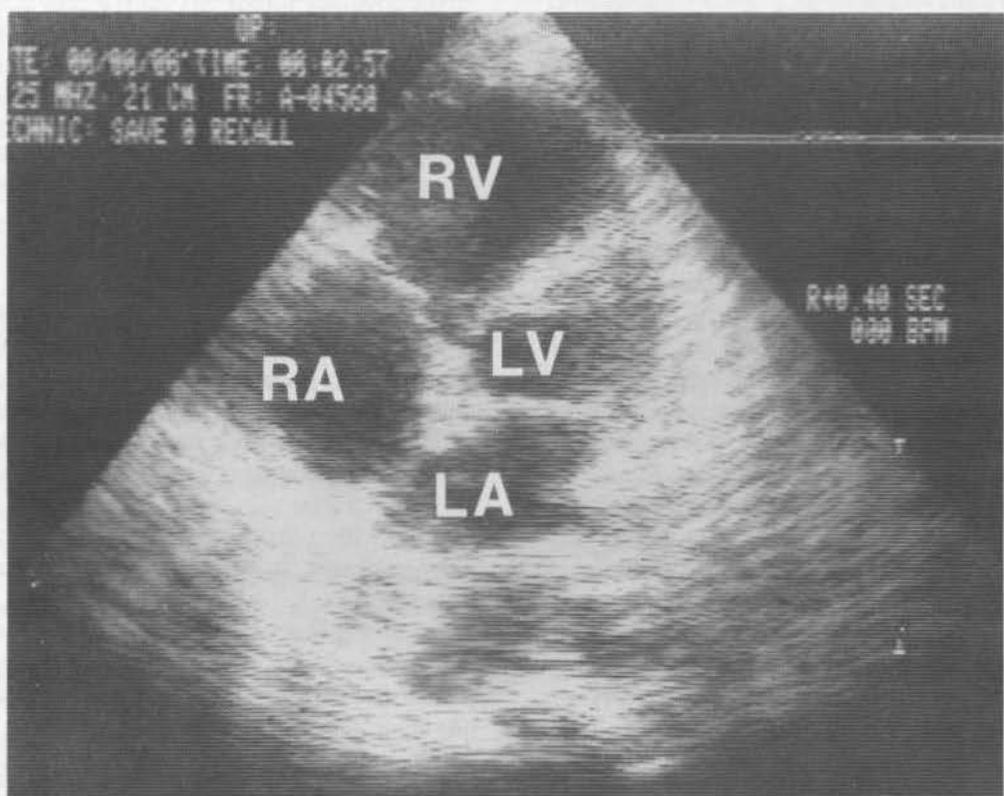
2-D, 4-chamber apical echocardiogram taken immediately post pericardial tap, revealing no significant pericardial effusion. (RV-right ventricle, RA-right atrium, LV-left ventricle, LA-left atrium).
